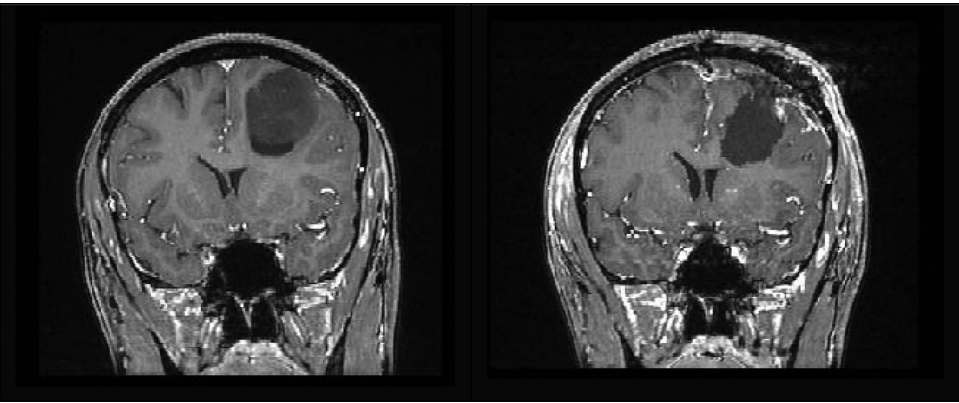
MR images for patient #11. Left: preoperative MRI. Right: postoperative MRI.
